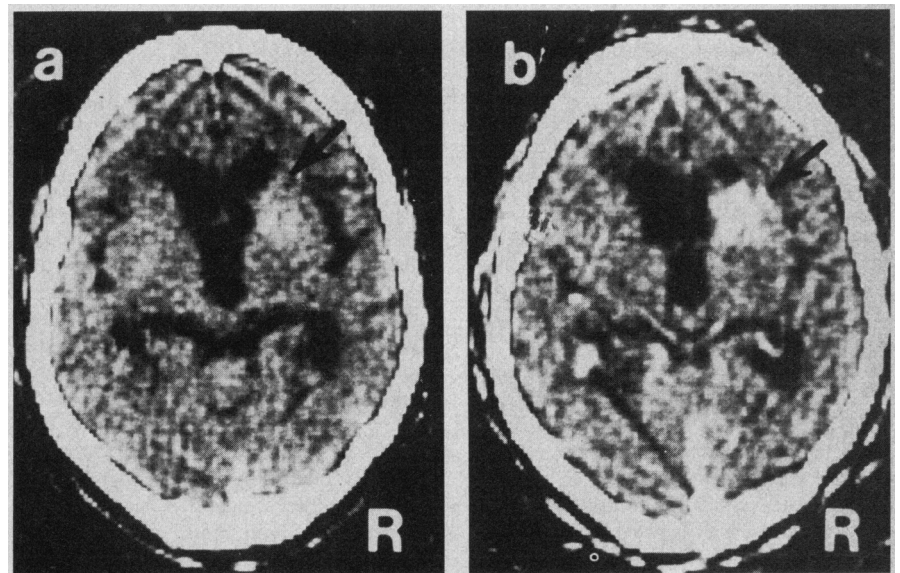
Case 5. a, Precontrast CT scan showing calcium-containing, well-circumscribed lesion in right caudate nucleus and internal capsule (arrow); no mass effect. b, Enhancement of lesion after contrast (arrow).
